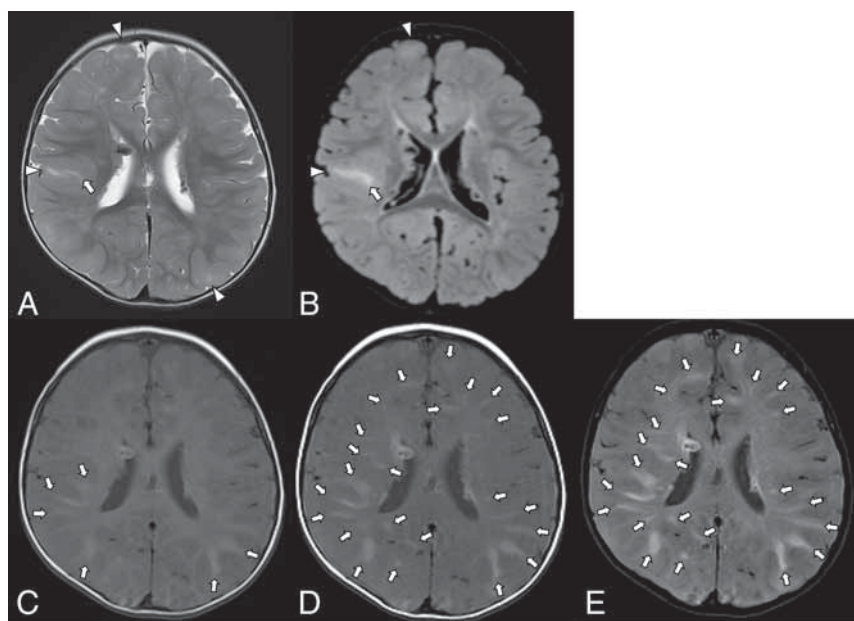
Patient 19. A 26-month-old boy. Axial T2WI (A), FLAIR (B), TIWI (C), TIWI-MTC (D), and TIWI-CHES (E). T2WI and FLAIR images demonstrate swelling of the cortex and subcortical hyperintensity, plus a linear hyperintensity extending to the ventricle, representing cortical tubers and RMLs, respectively (A and B, arrowheads and arrows, respectively). On TIWI, several RMLs can be seen as hyperintensity (C, arrows). The RMLs are more apparent on TIWI-MTC and especially on TIWI-CHES (D and E, arrows).
